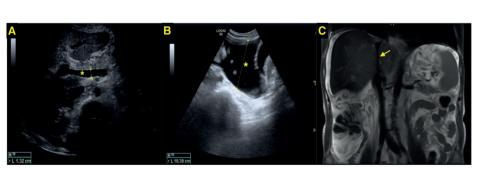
A. Abdominal ultrasonography showed portal vein dilatation (asterisk). B. Abdominal ultrasonography showed ascites collection (asterisk). C. Inferior vena cava (IVC) stenosis (arrow) was seen in magnetic resonans imaging (MRI).
